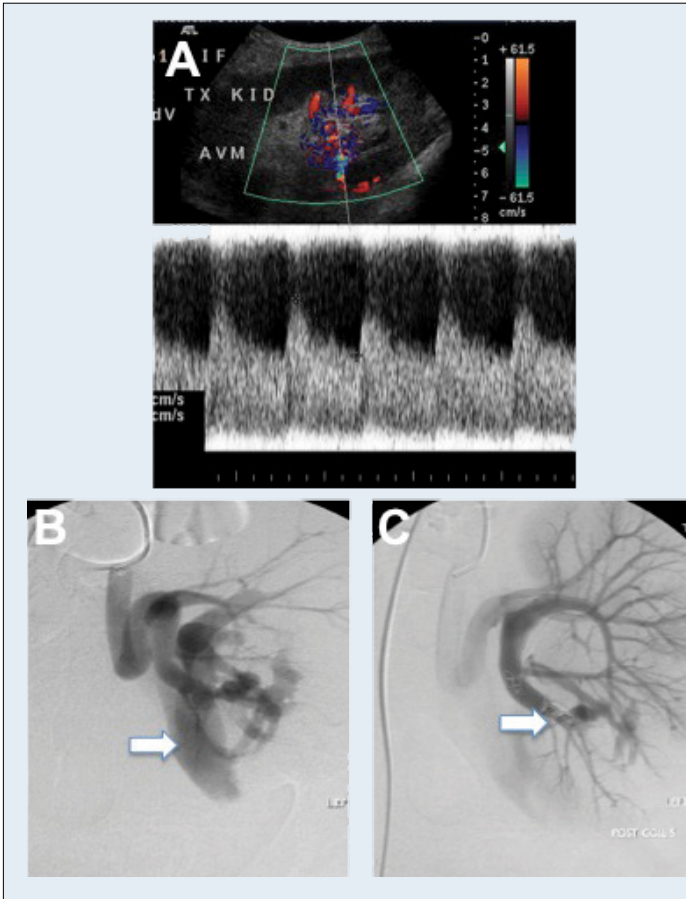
(A) Renal doppler ultrasound with an area of abnormal vascularity in the lower pole of the transplanted kidney with high velocity waveforms measuring between 240 and 340 cm/sec. (B) CT Angiogram showing arteriovenous malformation (AVM). (C) CT Angiogram post embolisation of AVM.
